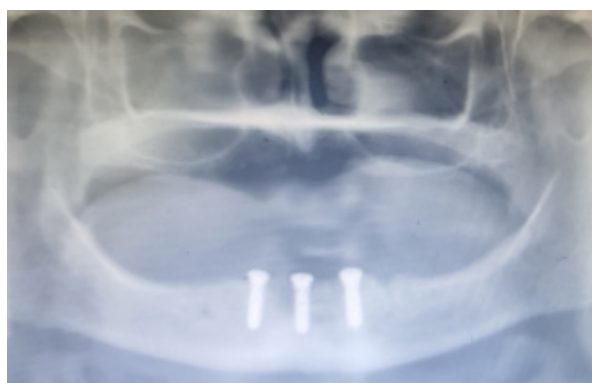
Panoramic radiography after implant insertion.
